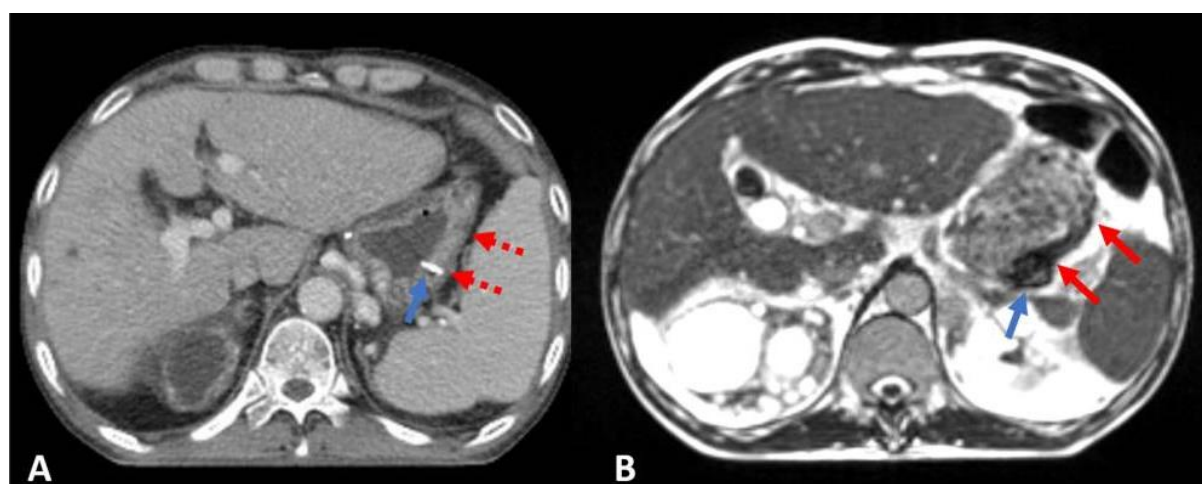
A type III GOJ tumour (arrowed) extending into stomach on CT (image A), T2 fat saturated MRI (image B) and diffusion weighted MRI (DWI - image C). Though difficult to differentiate tumour from normal stomach wall on CT, T2 imaging shows the tumour more clearly contrasted by fluid content, and on DWI tumour restriction results in the tumour appearing brighter than normal gastric wall.
